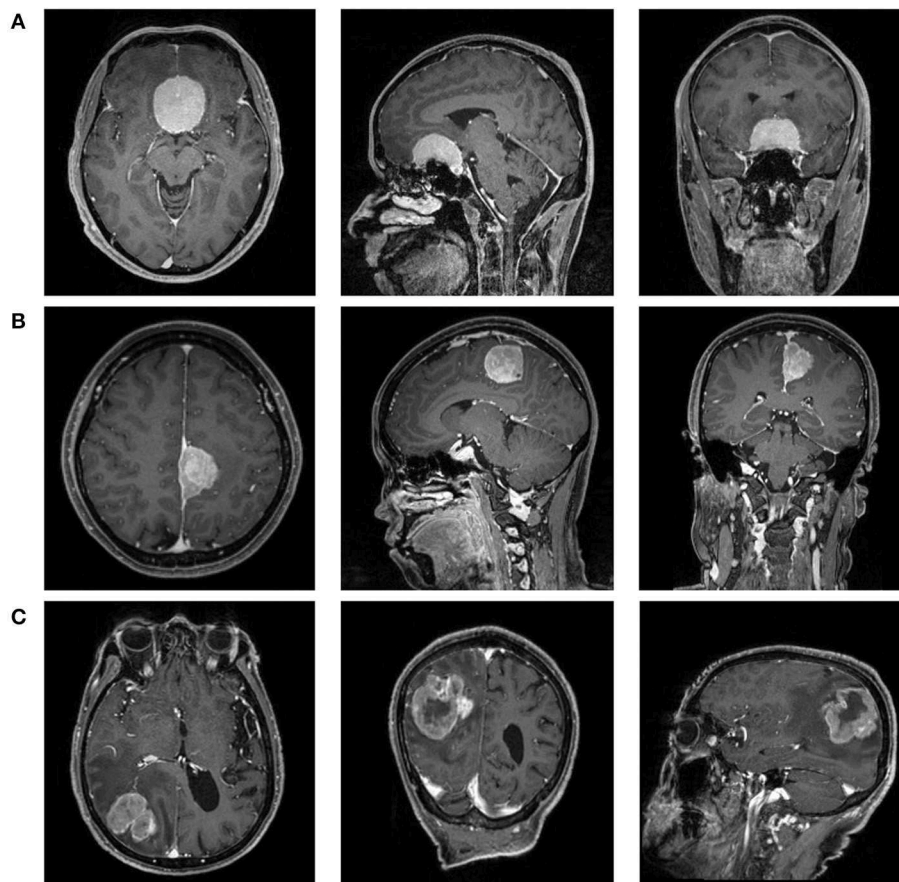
The magnetic resonance images [postcontrast T1-weighted (T1C)] of a patient with (A) WHO I meningioma, (B) WHO II meningioma, and (C) WHO III meningioma.
